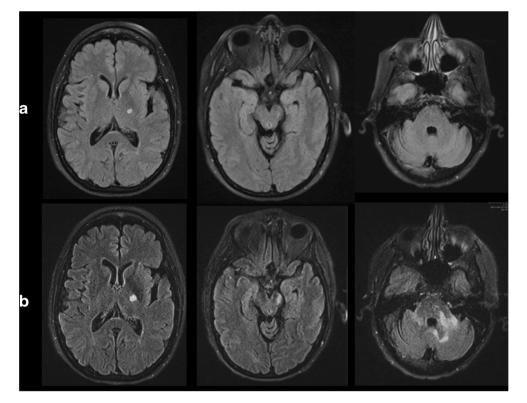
Progressive brain lesions of PML. Axial FLAIR MR images from the first MRI (a) show a lesion in the left thalamus (*left*), but no abnormality in the cerebral peduncles (*middle*) or cerebellum (*right*). Axial FLAIR MR images (b) obtained 6 weeks later show slight progression of the left thalamic lesion (*left*), as well as new lesions in the left cerebral peduncle (*middle*) and bilateral cerebellum (*right*)
